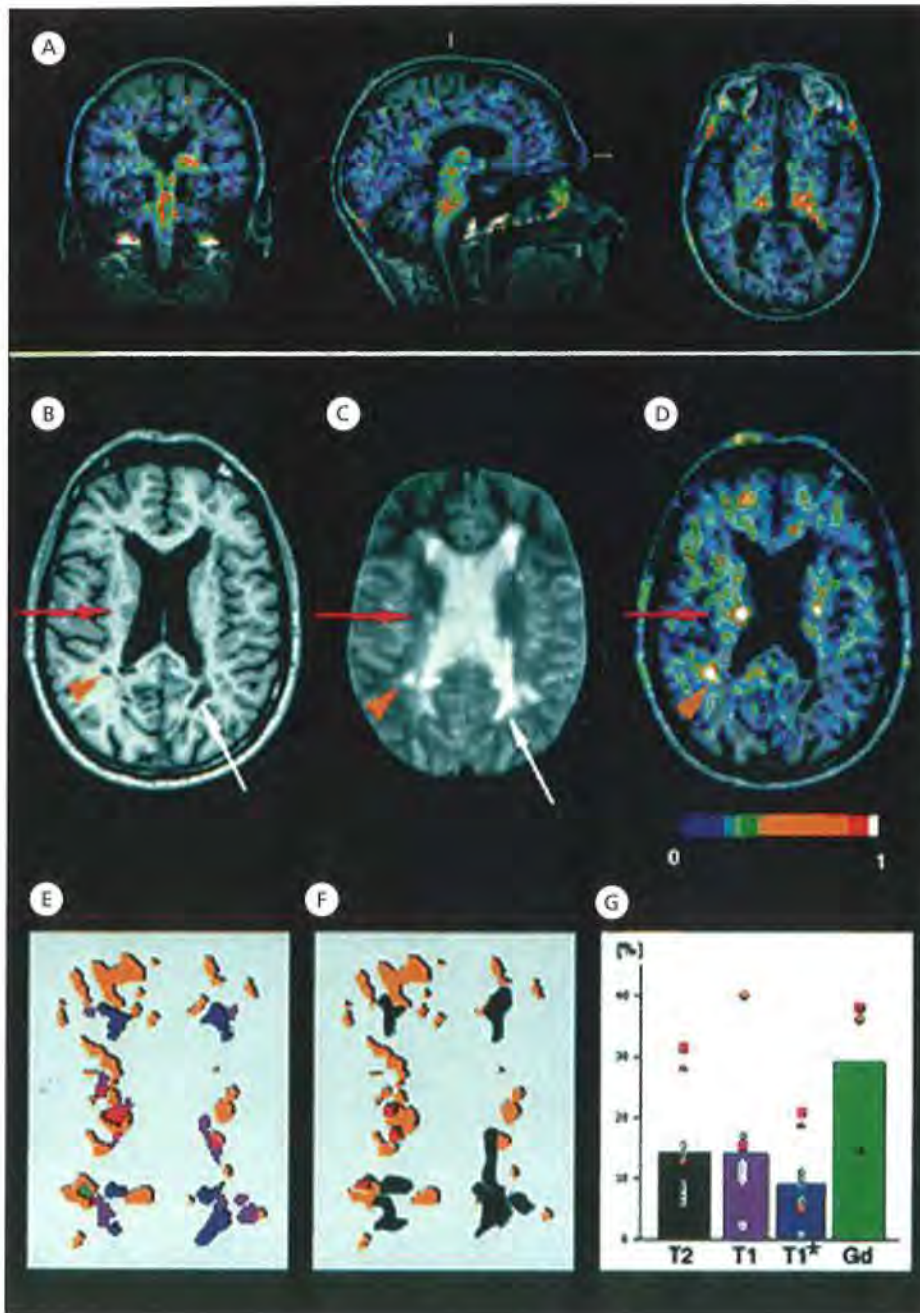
MRI and [^{11}C](R)-PK11195 PET. All images follow the radiological convention, i.e. the left side of the image corresponds to subject's right side. (A) Three orthogonal views of [^{11}C](R)-PK11195 images co-registered and overlaid on the MRI of Patient 9, showing spinothalamic tract-associated [^{11}C](R)-PK11195 signals extending through the brainstem and pons into the thalamus. (B–D) T₁-weighted (B) and T₂-weighted (C) MRI and [^{11}C](R)-PK11195 PET (overlaid on to T₁-weighted MRI) (D) of Patient 9 show lesions in all different spin-echo MRI sequences that partially overlap with areas of significantly increased [^{11}C](R)-PK11195 binding (red arrow). The white arrow points to a 'black hole' in an area that appears strongly hypointense in the T₁-weighted MRI and has little binding of [^{11}C](R)-PK11195. Note, however, that a similar black hole (yellow arrowhead) adjacent to the right occipital horn of the lateral ventricle shows significant [^{11}C](R)-PK11195 binding. (E–F) Demonstration of the definition of the MRI lesion load masks in Patient 9 (purple, T₁-weighted MRI lesions excluding black holes; blue, black hole only; green, gadolinium-enhancing areas; dark grey (in F), T₂-weighted MRI lesions; red, areas of overlap between significantly increased [^{11}C](R)-PK11195 binding and MRI-defined areas of pathology); yellow, areas of increased [^{11}C](R)-PK11195 binding and no overlap with any MRI-defined pathology. (G) Average percentage volume of the MRI-defined lesions overlapping with increased [^{11}C](R)-PK11195 binding. The red square represents Patient 8 and the red triangle Patient 6, who were both in relapse at the time of the scans. The yellow diamond represents Patient 9, who had secondary progressive multiple sclerosis. T1*, black holes.
